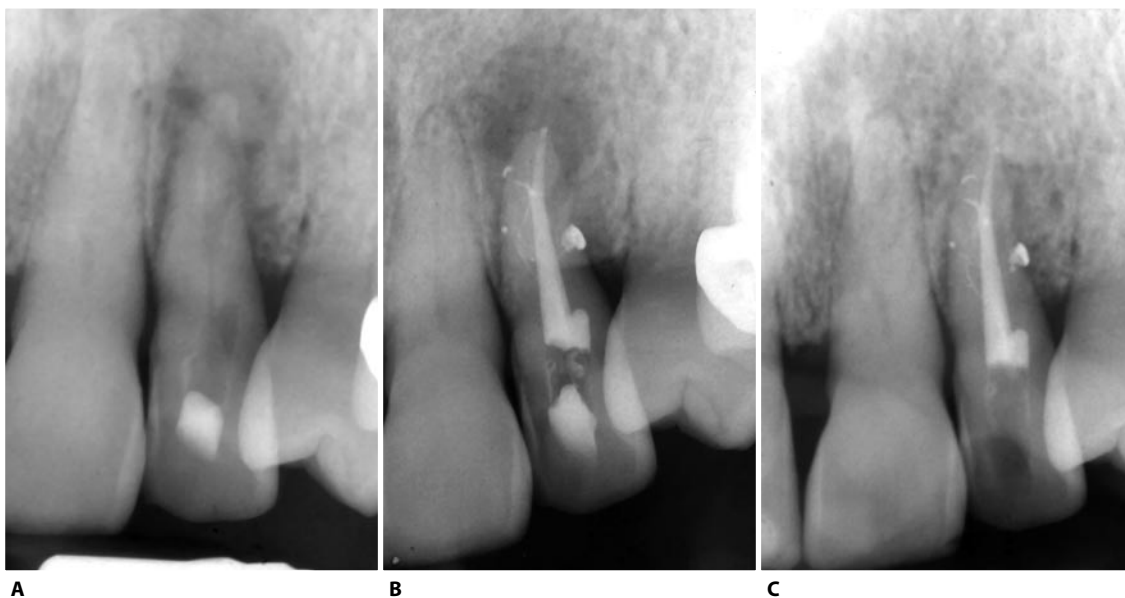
A. Pre-operative radiograph of a lateral incisor with a periradicular lesion that has formed and extended around the circumference of the root—form osseous crest to osseous crest. Very suggestive of root fracture, however the attachment apparatus was intact—there were no abnormal pocket depths. The tooth was accessed while the patient was on vacation (not my access preparation). B. Post-operative radiograph showing a complex root canal system with five portals of exit symmetrically positioned relative to the asymmetric lesions of endodontic origin. Occam's Razor would suggest a cause and effect. Patient's treatment time was one hour, my time in the case was 18 minutes. C. Recall radiograph showing healing at six months post-op.
